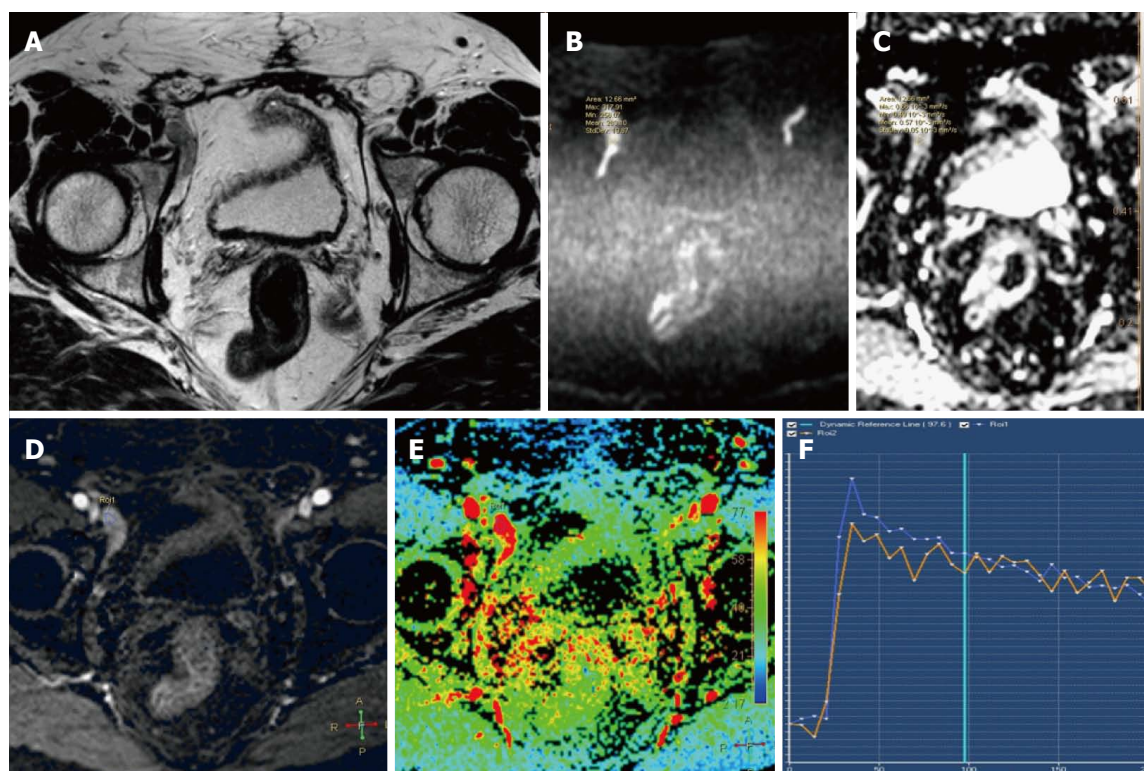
Lymph node study. A: Axial T2-weighted fast-spin echo image shows right external iliac lymph nodes; B and C: Axial diffusion sequences; C: Restricted diffusion in ADC map; D: Axial gradient-echo T1-weighted perfusion image showing a high peak enhancement; E: Color map; F: Curve; ADC: Apparent diffusion coefficient.
